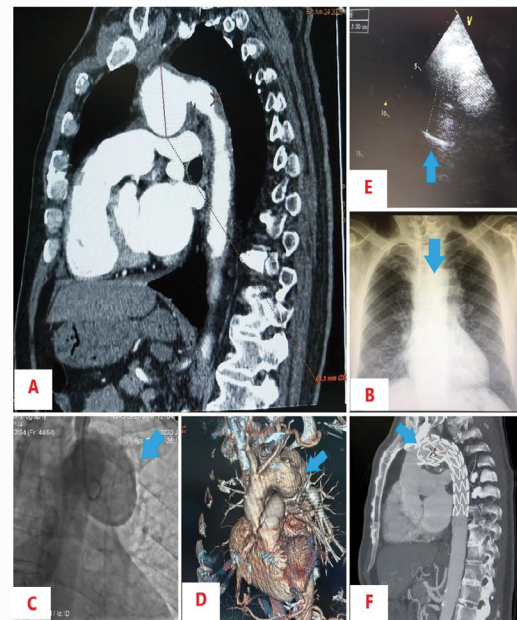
A) Computed tomography, sagittal view depicting the saccular aortic arch aneurysm with diameter of 54 mm pressing the trachea, B) Chest X-Ray showing the widening of the mediastinum (blue arrow), C) Infusion of contrast agent during the coronary angiography through a pigtail catheter showing the aneurysm (blue arrow), D) 3D reconstruction of the CT images, depicting the aortic arch aneurysm (blue arrow), E) Suprasternal view of heart ultrasound, depicting the aortic arch aneurysm (blue arrow), and F) Follow-up computed tomography, sagittal view, depicting the aneurysm covered by an endovascular stent graft.
